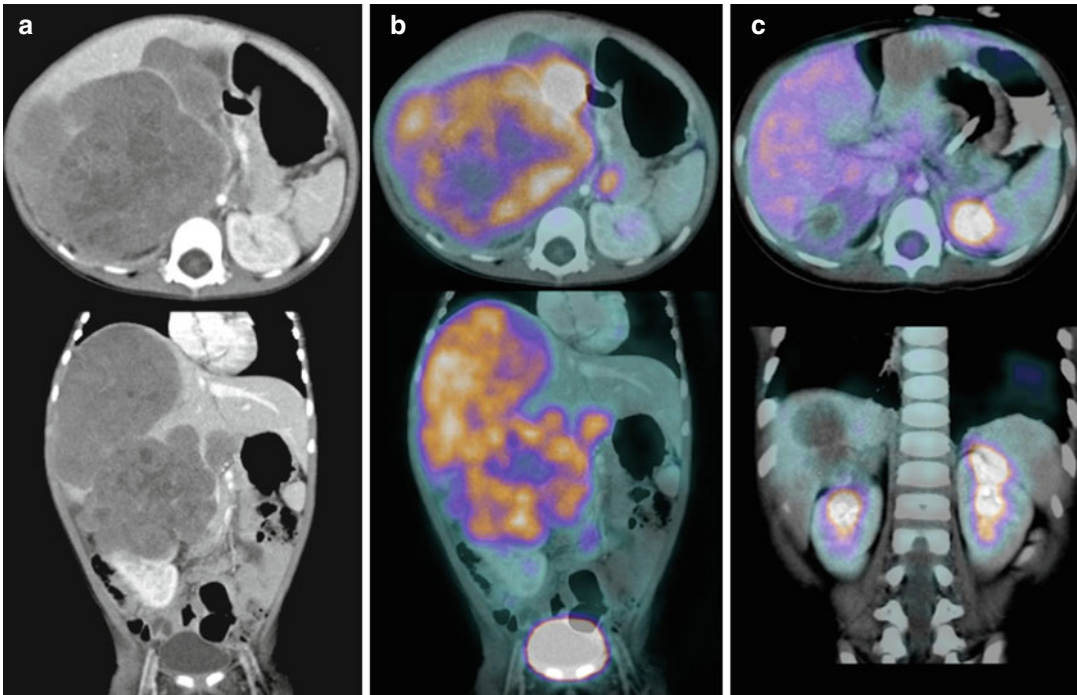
Wilms' tumor in a 20-month-old female who presented with a large right-sided abdominal mass. Fluorine-18-FDG PET/CT scan at initial staging (a, b: *top* axial; *lower* coronal) shows a large mass arising from the right kidney with central necrosis and multiple metastases
